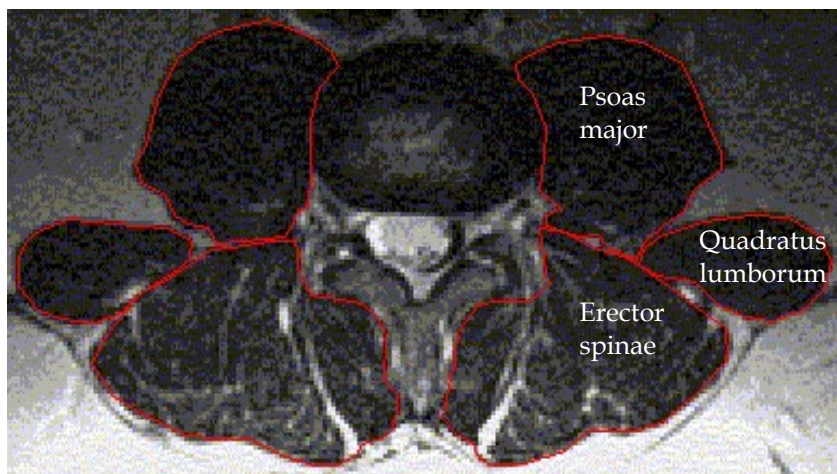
Axial MR image at the level of the L3-L4 disc with tracing around the erector, quadratus lumborum and psoas major muscles.
